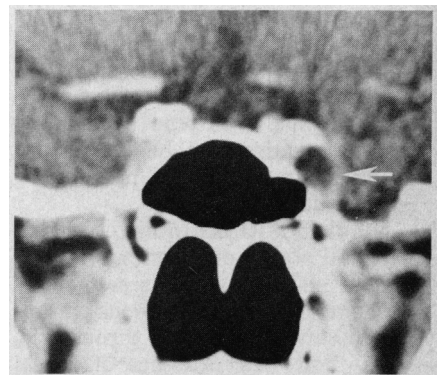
Contrast-enhanced coronal computed tomographic scan demonstrating bulging of left cavernous sinus by nonenhancing mass (arrow).
